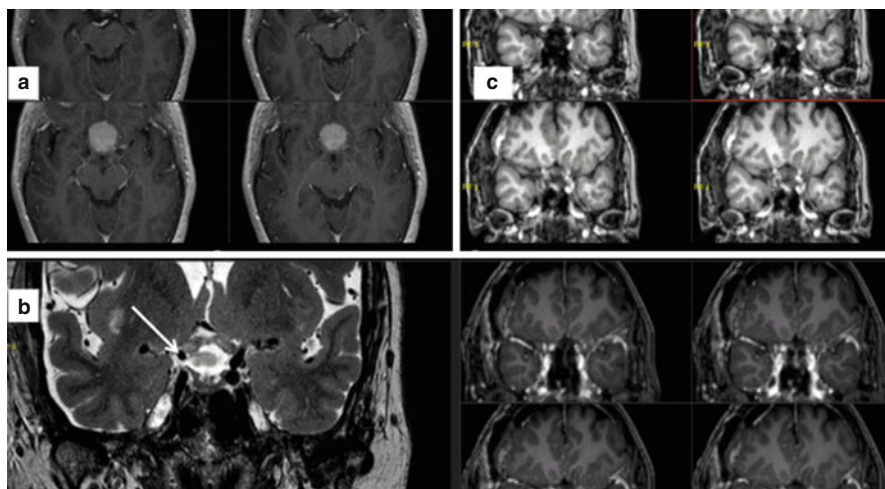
Tuberculum sellae meningioma – postop further worsening of preoperatively severely affected vision right ON due to focal ischemia (s. *arrow*) due to small terminal optic nerve arteries (a) preop MRI; (b, c) postop MRI
